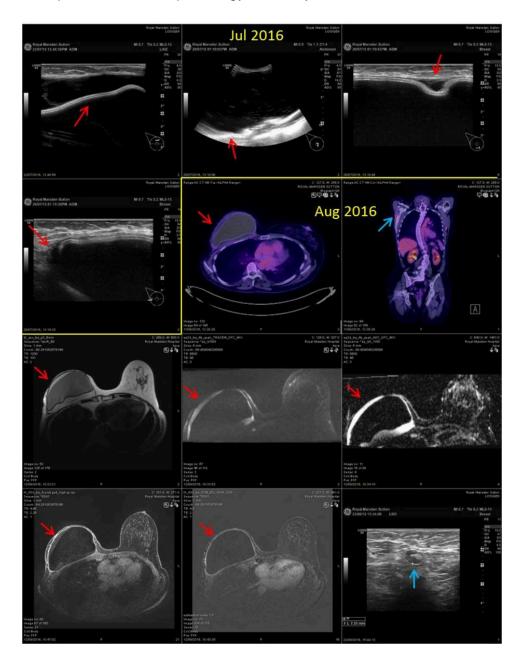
CASE 3 - 50-year-old lady with right mastectomy and axillary node clearance followed by latissimus dorsi flap and implant reconstruction in May 2005 for a 6 cm, grade I invasive lobular carcinoma, ER7, PR8, HER2 negative, 0/12 lymph nodes. Consequent adjuvant chemotherapy (4 cycles of doxorubicin and cyclophosphamide), radiotherapy 50 Gy, and adjuvant tamoxifen. 3 further reconstructive breast operations, one in 2006 and two in 2015. Furthermore, her past medical history included right hip replacement in April 2016, spinal scoliosis, previous tonsillectomy, endometriosis (two laparoscopies in the past), cervical intraepithelial neoplasia treated with laser. Assisted conception. In 2015 lumpiness along the right lateral breast developed. No B symptoms (fever, night sweats, and weight loss). IMAGING: An ultrasound scan performed in June 2015 showed
